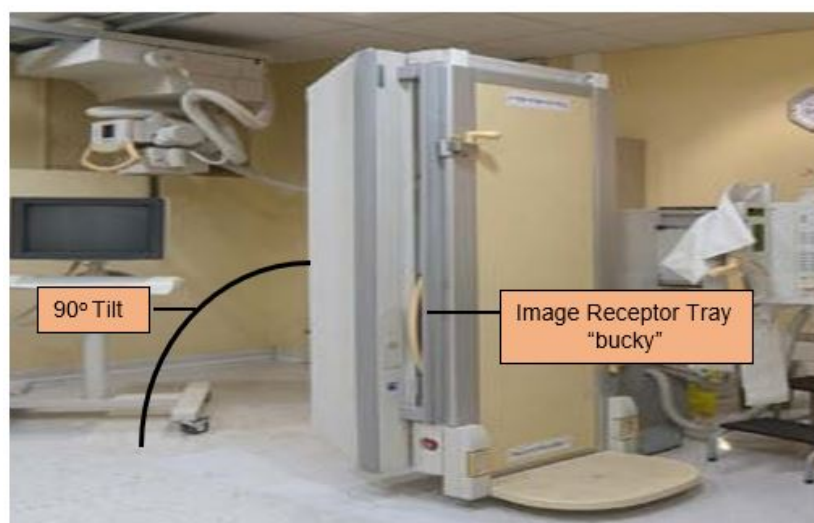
X-ray tilt table.
